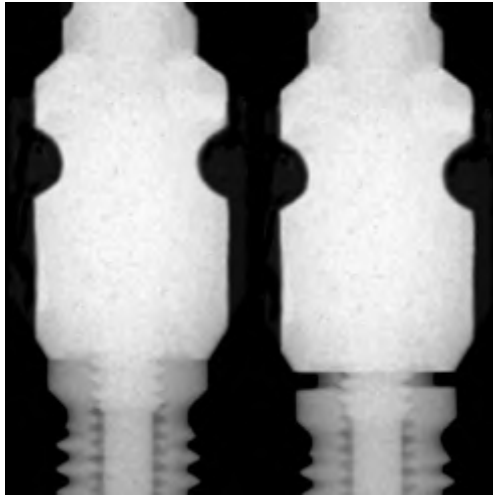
Radiographs that demonstrate an impression coping seated onto an implant restorative platform (left), and not seated onto an implant restorative platform (right).
